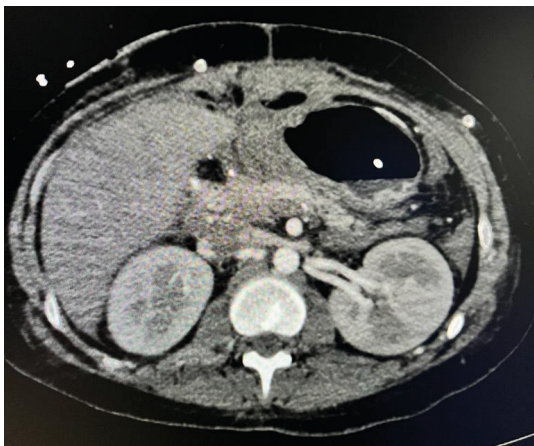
Full abdomen CT, arterial phase, post-enucleation of Frantz's tumor in the head of the pancreas.
